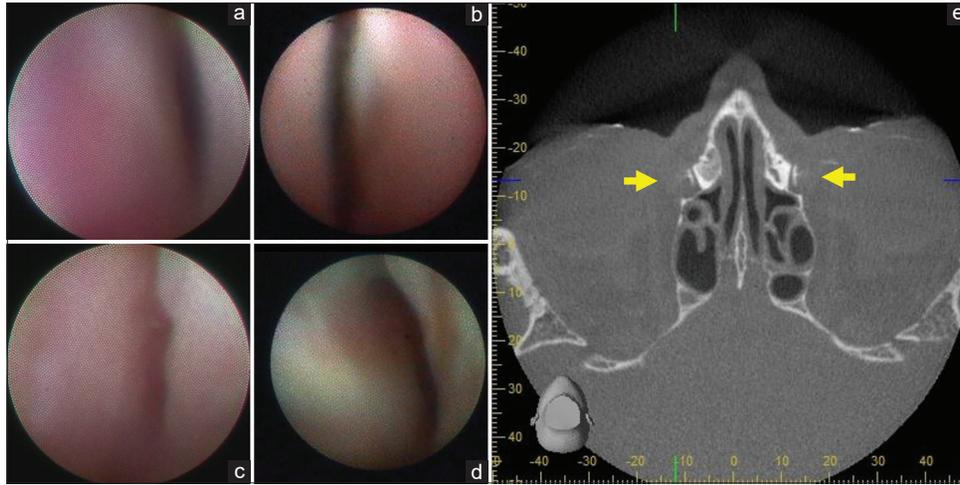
Slit sign in lacrimal sac. (a-d) Dacryoendoscopic images showing the slit sign, indicating a fully patent nasolacrimal duct (NLD). The slit sign has a sensitivity of 92% and specificity of 84% for determining NLD patency (Jpn J Ophthal Surg 2023;36 (2):271-75, [in Japanese]). (e) Horizontal computed tomography-dacryocystography image showing the slit sign (yellow arrow). Slit sign (a) observed in case (e), right-side lacrimal outflow system
